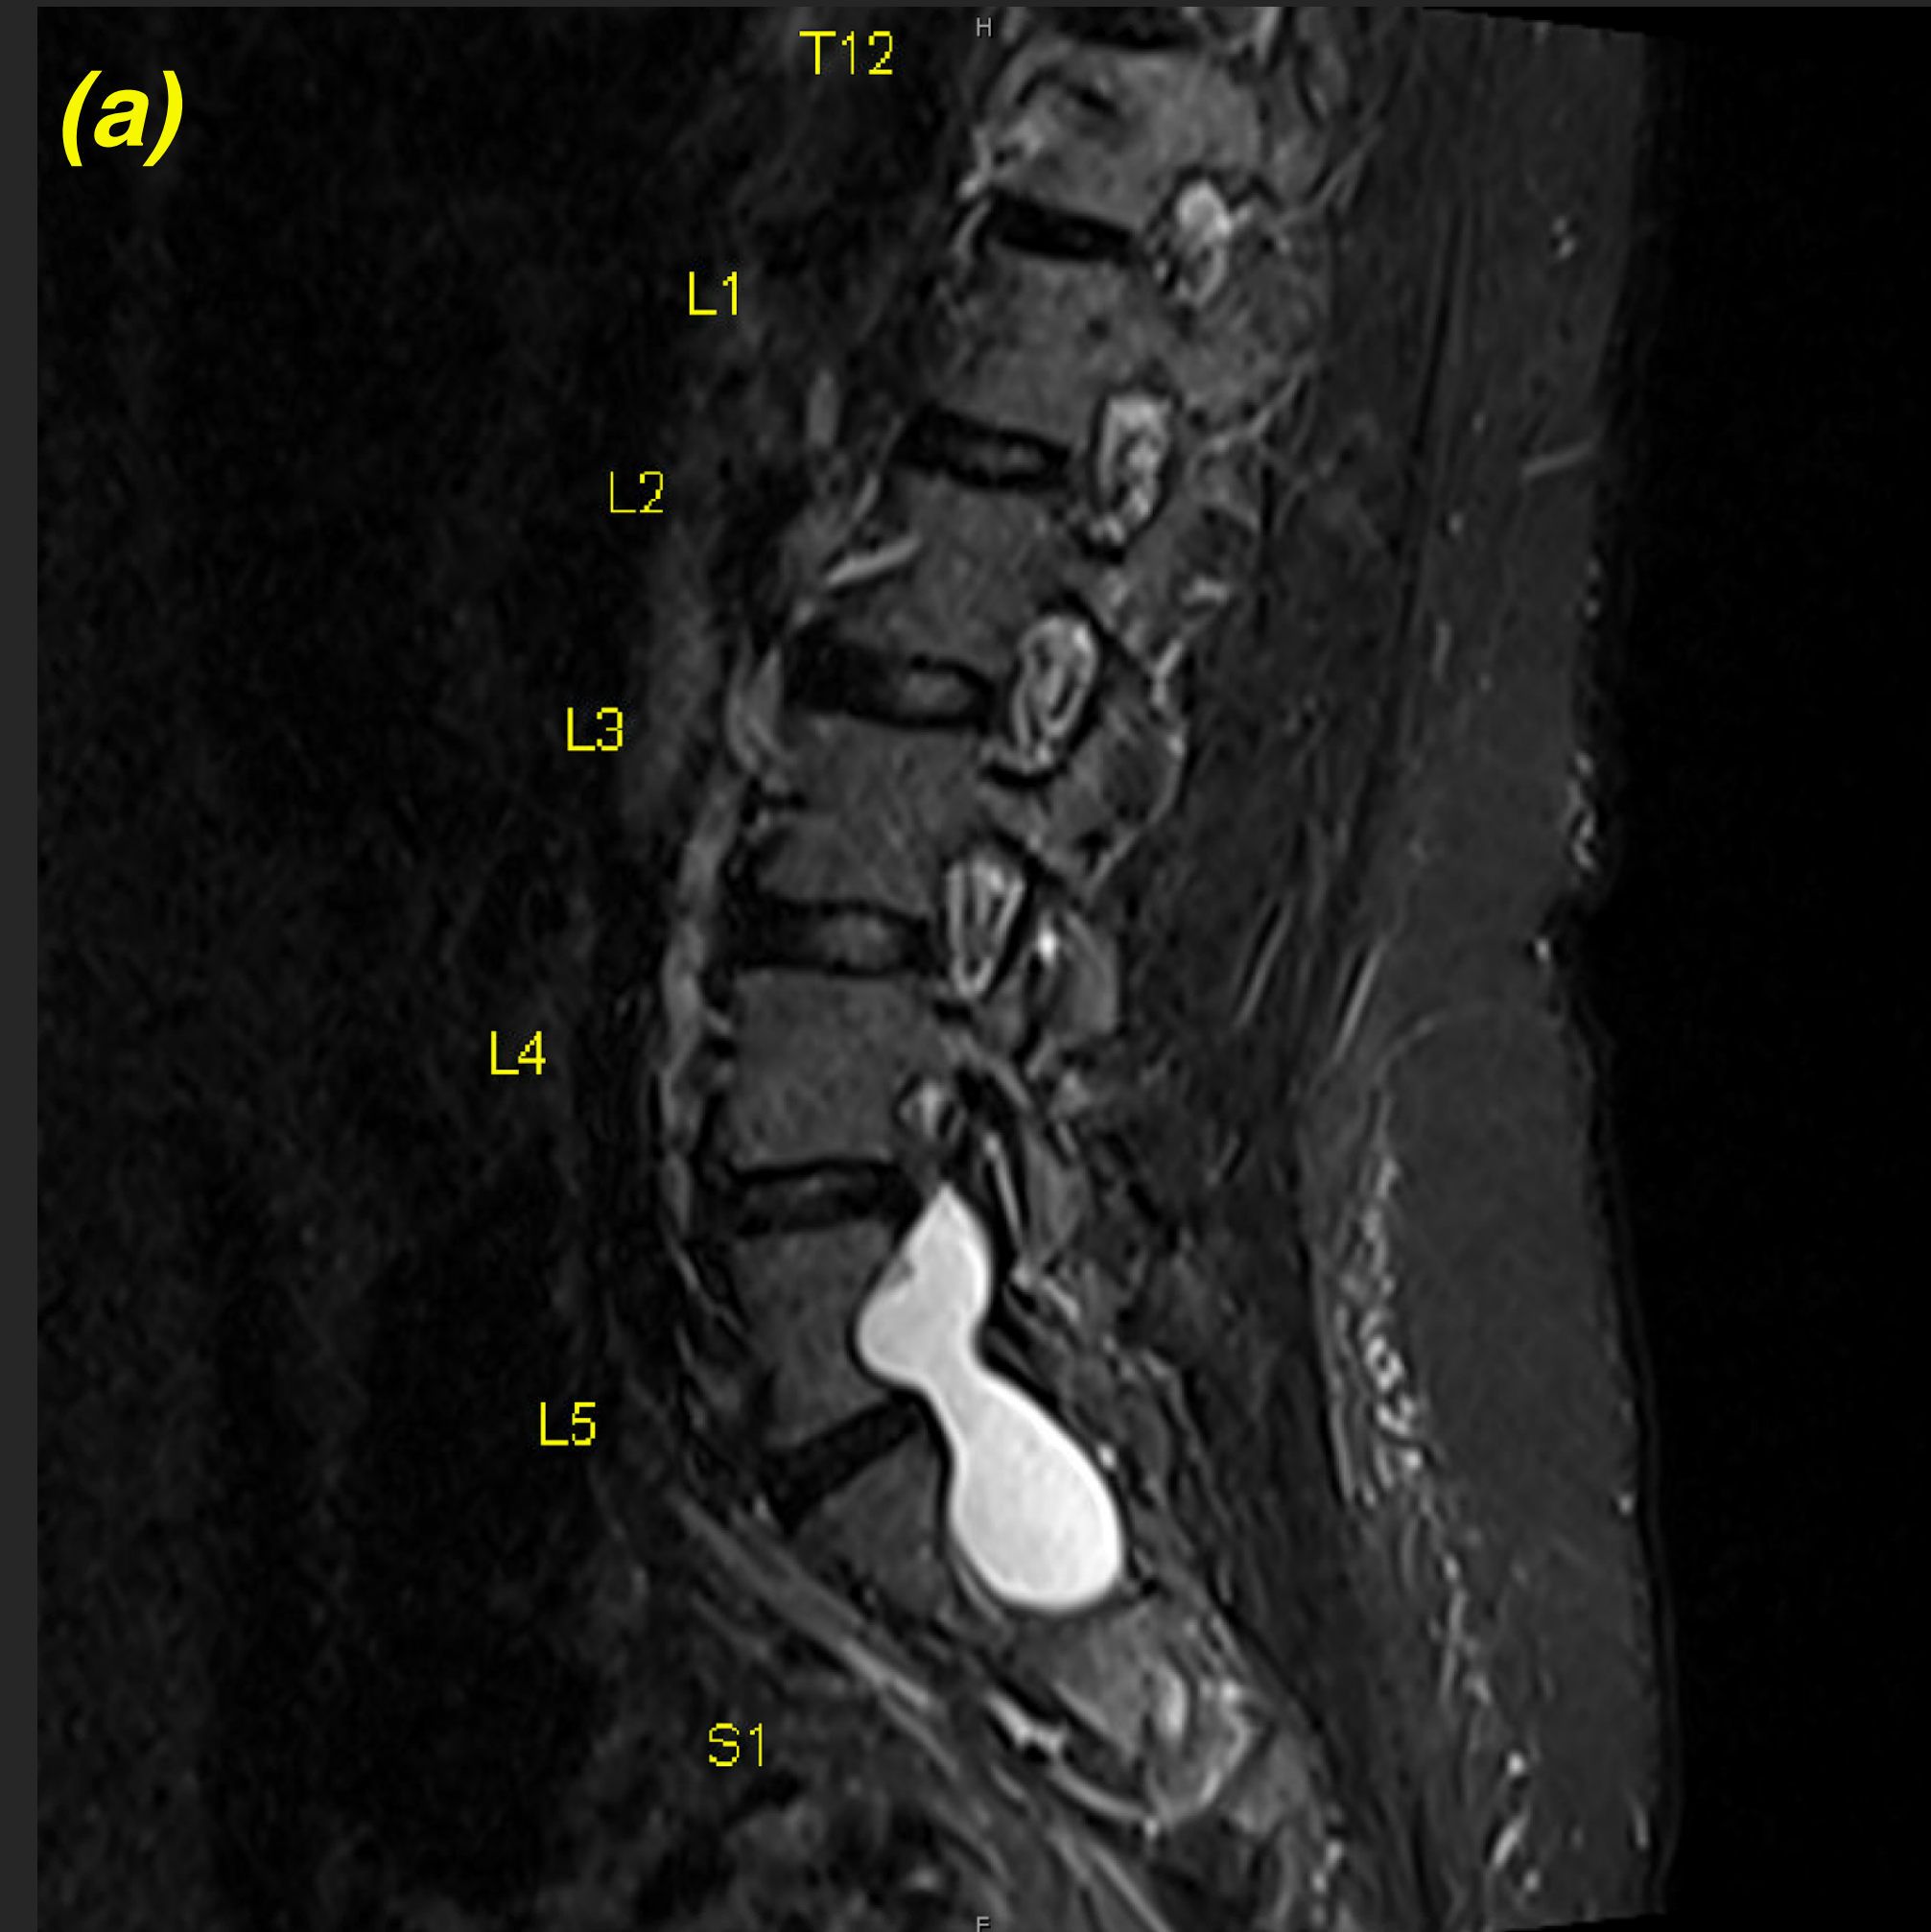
MRI of lumbar spine without contrast, T2 weighted, sagittal view(a), transverse view(b) showing a Large Tarlov cyst seen in the left central canal at the L5 level, which displaces the left-sided cauda equina nerve roots antero-laterally towards the right. This cyst also extends into the left L5-S1 and S1 neural foramen where it displaces the exiting L5 and S1 nerve roots.
